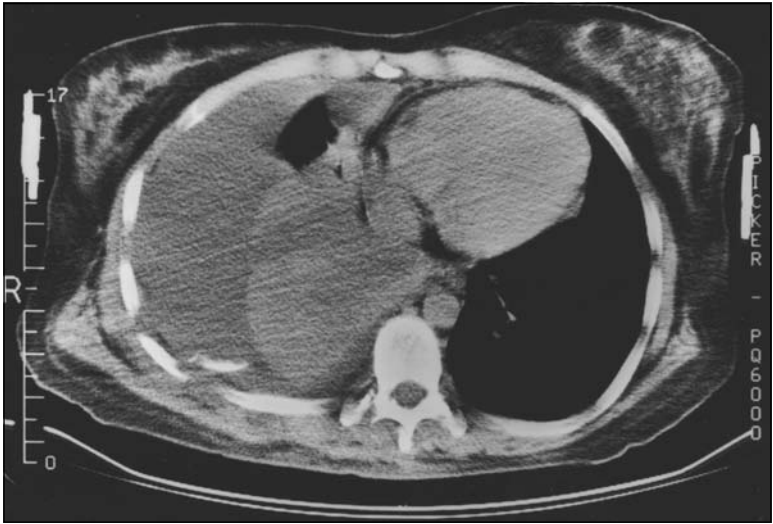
CT scan of the above patient showing no evidence of loculations. Despite delayed presentation on postinjury day 12, the collection could easily have been evacuated using thoracoscopy techniques. A thoracotomy was performed, however, to facilitate stabilization of the chest wall defect.
